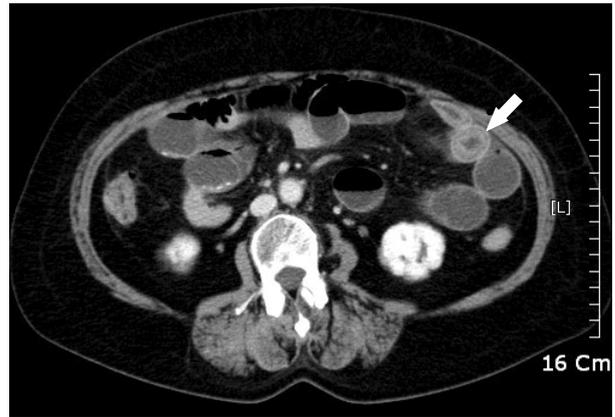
Abdominopelvic CT showed dilated small bowel loops filled with fluid and target shaped wall thickening of the jejunum (arrow) with luminal narrowing.
